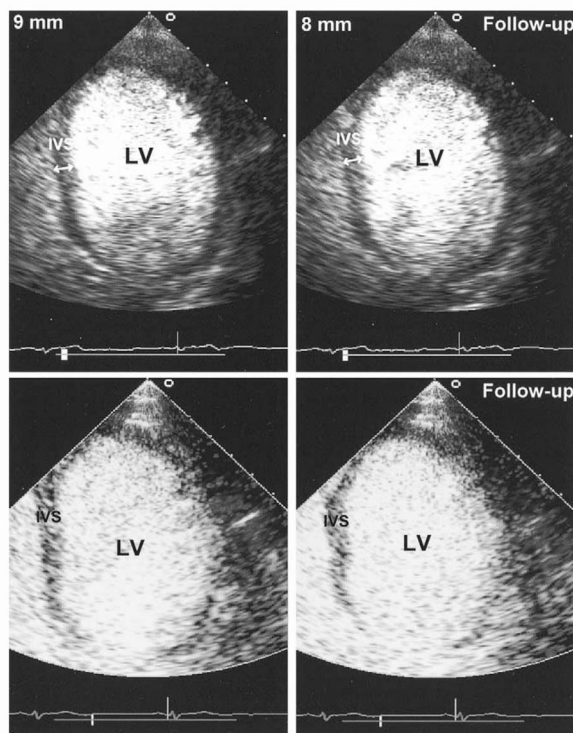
Two-dimensional echocardiograms showing end-diastolic wall thickness (upper panels) and perfusion (lower panels) in an infarcted region directly after percutaneous coronary intervention (left panels), and after recovery at two months' follow-up (right panels). IVS = interventricular septum; LV = left ventricle.
